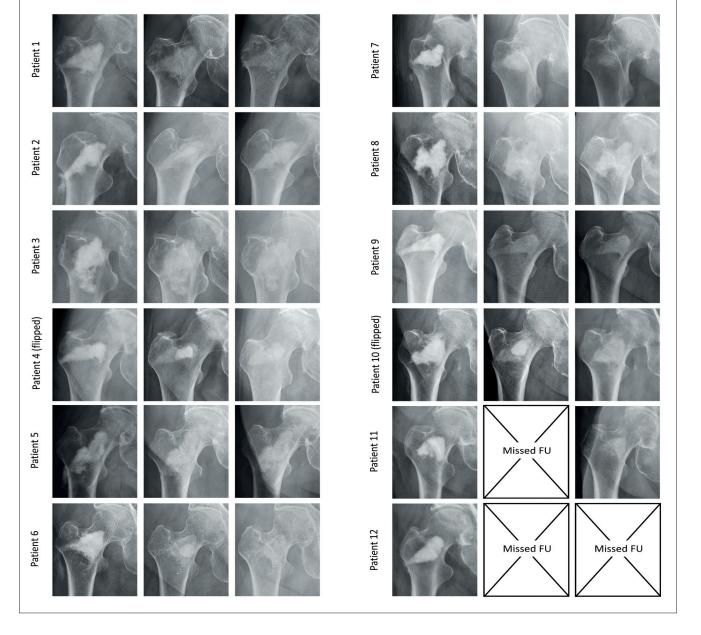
Matrix of X-rays showing AGN1 implant material resorption over time in all patients. The implanted material is progressively and completely replaced with radiopaque osseous structures corresponding to the originally filled basal neck and intertrochanteric regions after two years.
